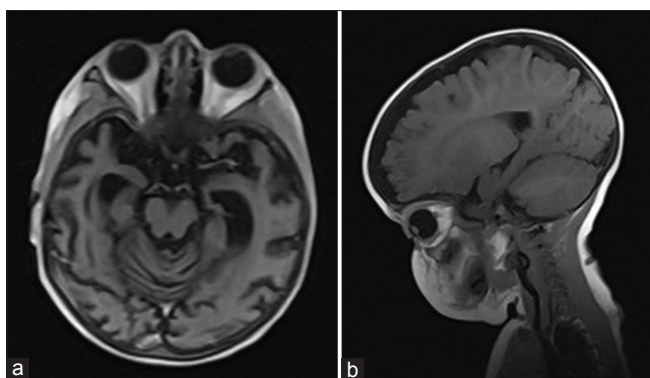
(a and b) T1-weighted magnetic resonance imaging axial and midsagittal brain images of a 6-year-old female. There is prominence of the subarachnoid spaces due to cerebral atrophy
